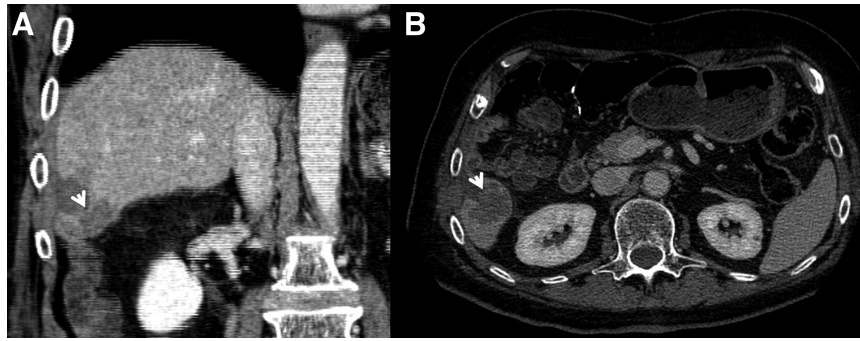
A 48-year-old woman with colorectal liver metastasis on VI hepatic segment treated with radiofrequency ablation. In (A) (Multiplanar reconstruction in coronal plane) and (B) (Multidetector CT in axial plane during portal phase of contrast study), incomplete ablation with residual disease (arrow) that shows less hypodense feature compared with ablated zone.
